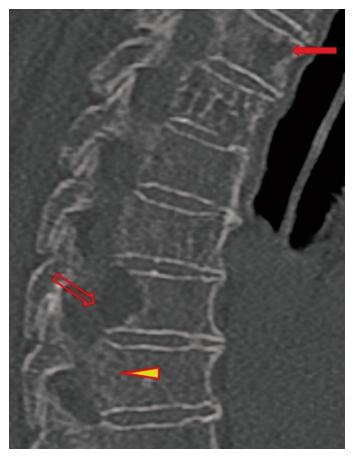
Vertebral lymphoma. Sagittal, CT scan of thoracic vertebrae shows *multilevel involvement* of lytic bone destruction (*closed arrow*) with extension into the vertebral canal and vertebral disc (*open arrow*), and permeative bone destruction (*arrowhead*).
